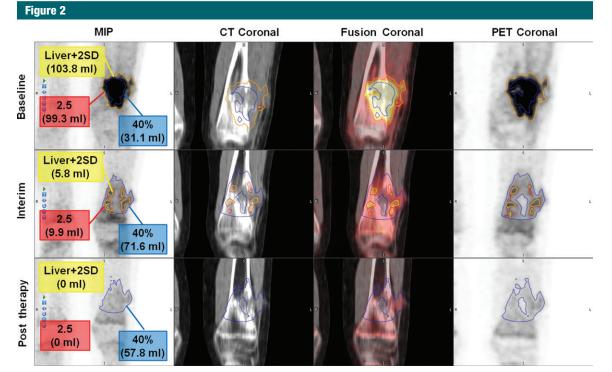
Representative case showing overestimation of metabolic tumor volume (*MTV*) by relative threshold at interim and posttherapy scans. MTV was measured by using fixed (standardized uptake [*SUV*] threshold of 2.5, in red) and liver-based threshold (liver + two SDs [*2SD*], in yellow) predicts a favorable outcome at interim and posttherapy scan; however, MTV measured by using a relative threshold (40% of maximum SUV [*SUVmax*], in blue) overestimated the tumor volume at interim and posttherapy scan, thus incorrectly predict the outcome. The patient was free of disease at 54 months. The MTV values are in the parenthesis within the boxes (yellow, red, and blue) of maximum intensity projection (*MIP*) images.
